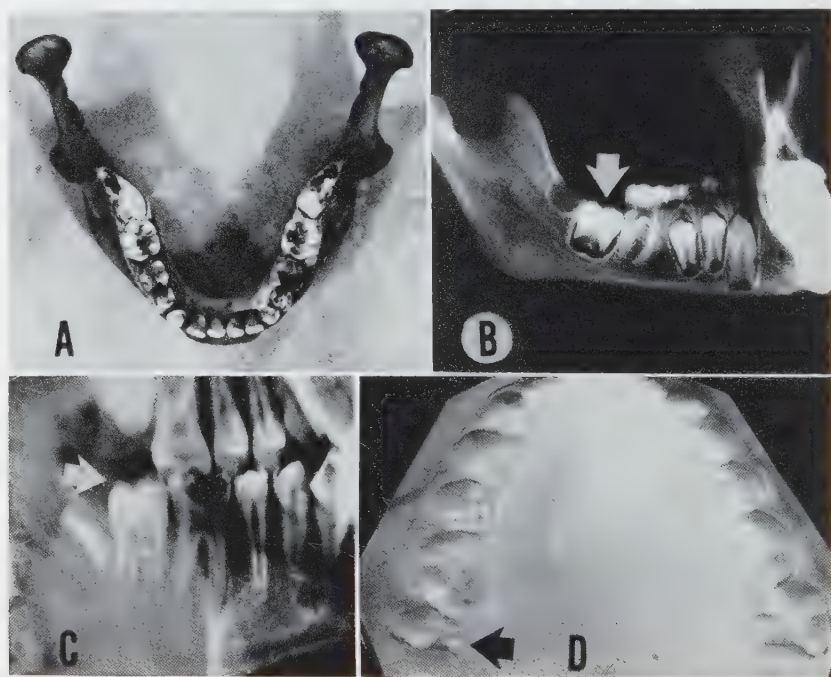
Examples of possible errors in determining the "eruption" sequence. A, mandible showing  $M_2$  in crypt,  $P_2$  not yet erupted; this suggests the  $M_2P_2$  eruption sequence. B, skiagram of the same mandible showing that  $M_2$  has not yet reached alveolar eruption, and  $P_2$  is more advanced in calcification. The true sequence *at this stage* would be  $P_2M_2$ . C, roentgenogram showing  $M_2$  apparently fully erupted at 11-1/2 years. D, cast made of same subject (Fels No. 87) one-half year later;  $M_2$  is still incompletely erupted clinically, and a  $P_2M_2$  sequence of gingival eruption would be assigned.
